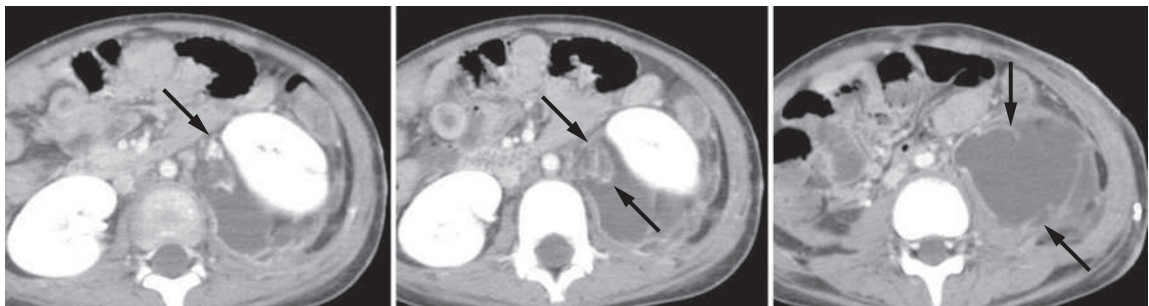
CT of the abdomen at 3 weeks after injury. The left kidney was displaced upwards with a collection of fluid at its lower pole (arrows). No parenchymal injury was noted.
